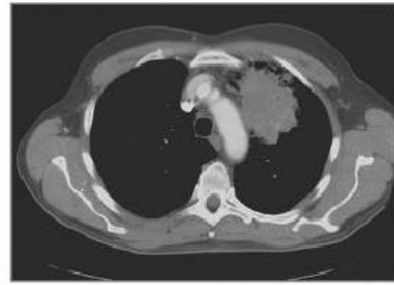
Lung Cancer CT Image
